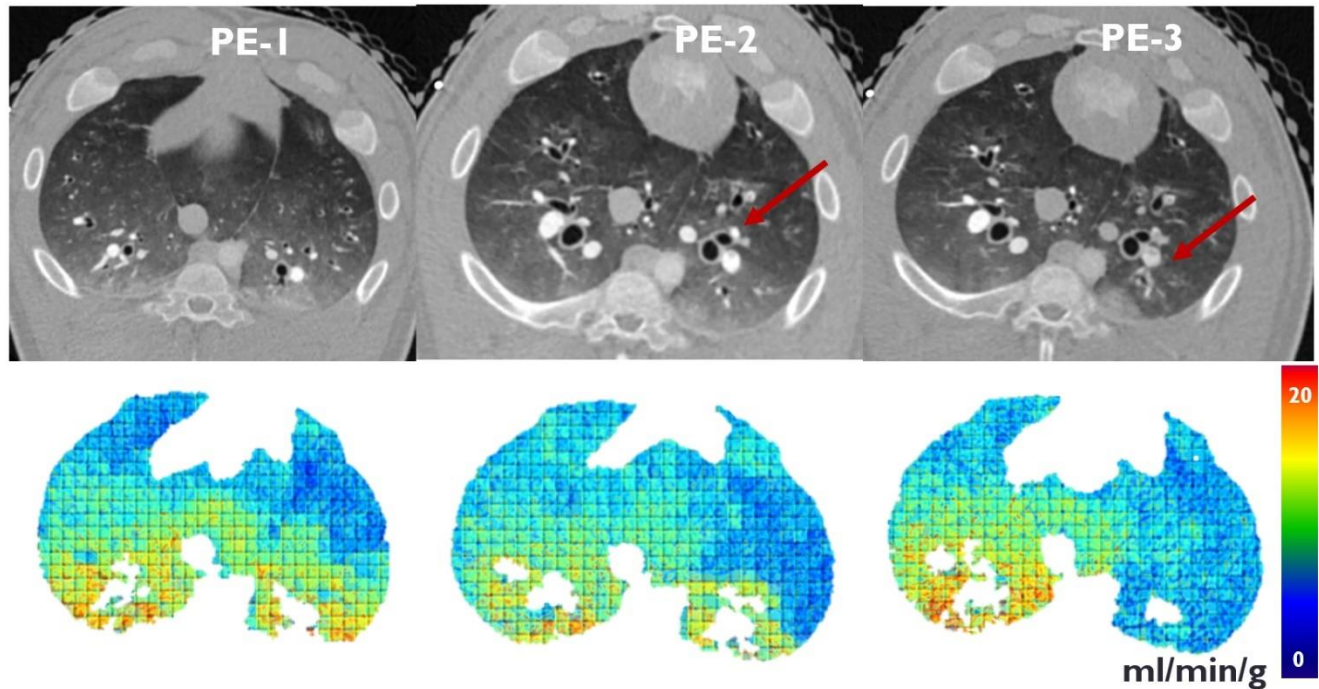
Two-volume, whole-lung CT perfusion distribution map with the presence of PE.
